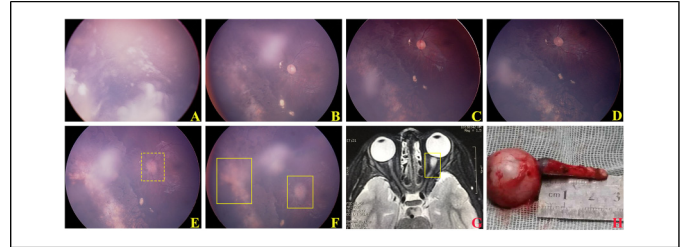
The fundus, orbital MRI, and surgery picture of Patient No. 6. (A) The fundus image of the patient before PPV. There were tumor growers with vitreous cavity seeds, which was diagnosed as RB stage D. The patient underwent 1 cycle of chemotherapy and 1 time of arterial intervention therapy. (B) The fundus image of the patient 3 months after PPV. The tumors were all cleared, and no residual or new lesions were found. (C) The fundus image of the patient 5 months after PPV. No new lesions were found. (D) The fundus image of the patient 7 months after PPV. There were old scars in the fundus. No new lesions were found in the eye. (E) The fundus image of the patient 9 months after PPV. There were suspicious lesions near the optic disc (shown in the yellow dotted box). The optic disc turned red with slightly blurred borders. (F) The fundus image of the patient 10 months after PPV. There were new lesions in the optic disc and the nasal retina (shown in the yellow solid box). (G) The orbital MRI results showed thickening of the left optic nerve in the orbital segment. (H) Patient underwent enucleation of the left eyeball and removal of 2.5 cm of the optic nerve. The excised segment of the optic nerve was thickened and dark.
